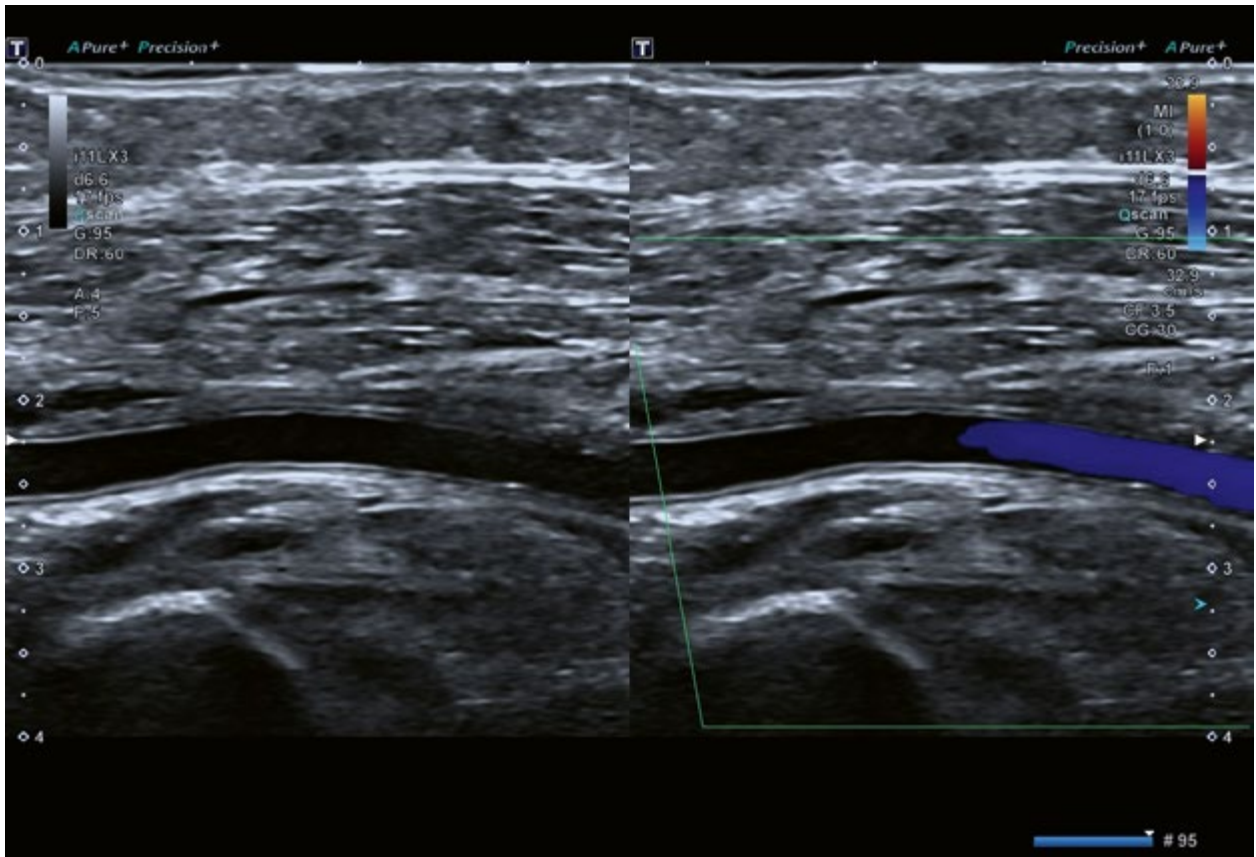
No changes in the right superficial femoral artery in ultrasonography
